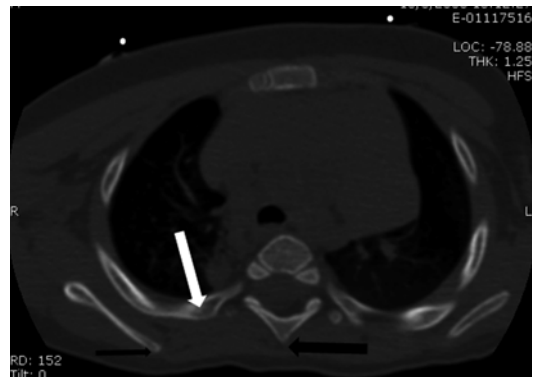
CT of the chest. Note that the attachment point of the rib anchor (*white arrow*) is in a trough with good soft tissue coverage between the spinous process (*thick black arrow*) and scapula (*thin black arrow*) (Reproduced with permission of Children’s Orthopaedic Center, Los Angeles)
